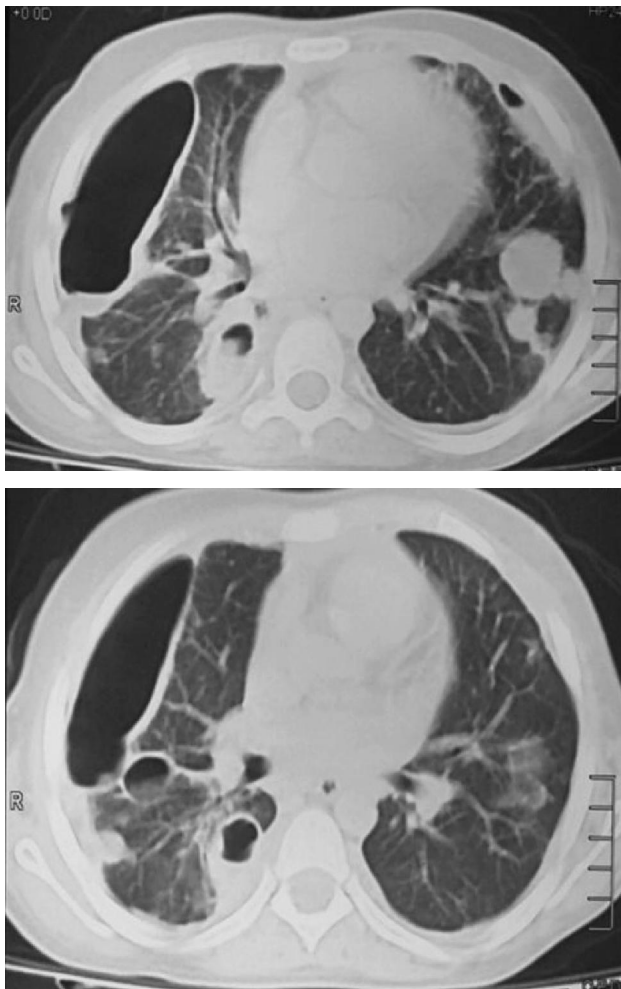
Axial sections of CT scan chest with contrast showing bilateral pneumothorax more on right side. Multiple pulmonary nodules of varying sizes seen in both lungs, peripherally distributed with feeding vessel sign. Few of the nodules showing cavitation.
